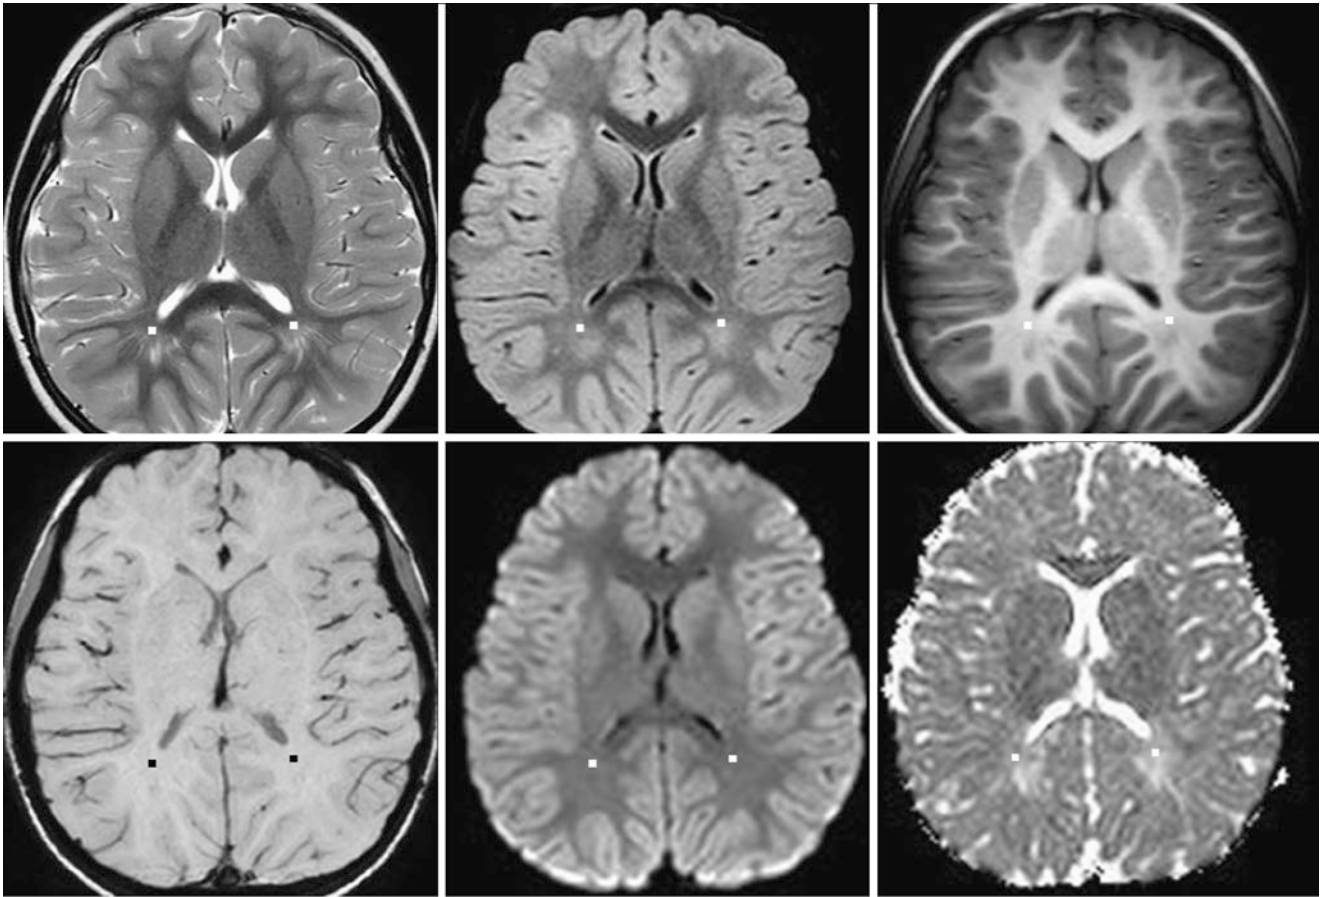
A 4.25-year-old with gait symptoms, with normal 3T SE T2WI (top left), 3D FLAIR (top middle), GE T1WI (top right), SWI (bottom left), DWI (bottom middle), and ADC map (bottom right). Note terminal zones bilaterally within the PTWM (squares) on T2WI, FLAIR, T1WI, and the ADC map, without corresponding abnormality on SWI or DWI
